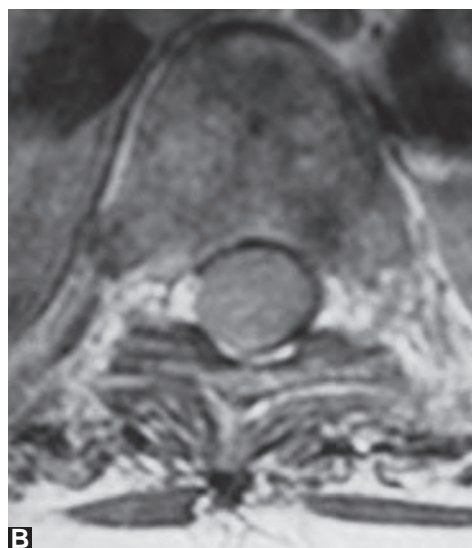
T2-weighted coronal MR image shows a dural based meningioma displacing and compressing the spinal cord to the right. Note the widened adjacent cerebrospinal fluid spaces
